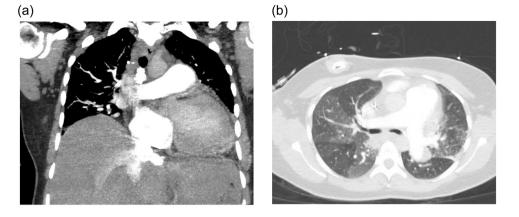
Representative images of computed tomography angiography of the chest. (a) Right middle and right lower perfusion defect in coronal view; reflux of contrast into the hepatic circulation is also apparent. (b) Bilateral mosaic attenuations and enlargement of the pulmonary trunk.
